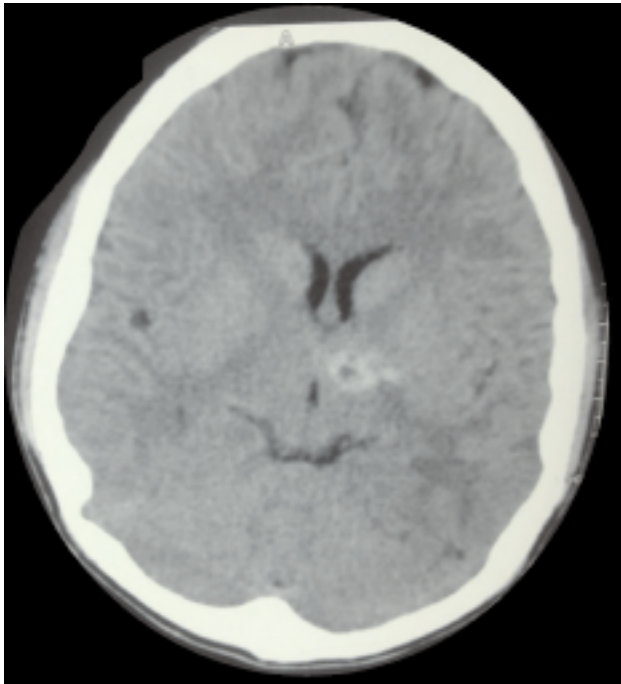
CT scan showing thalamic bleed.
